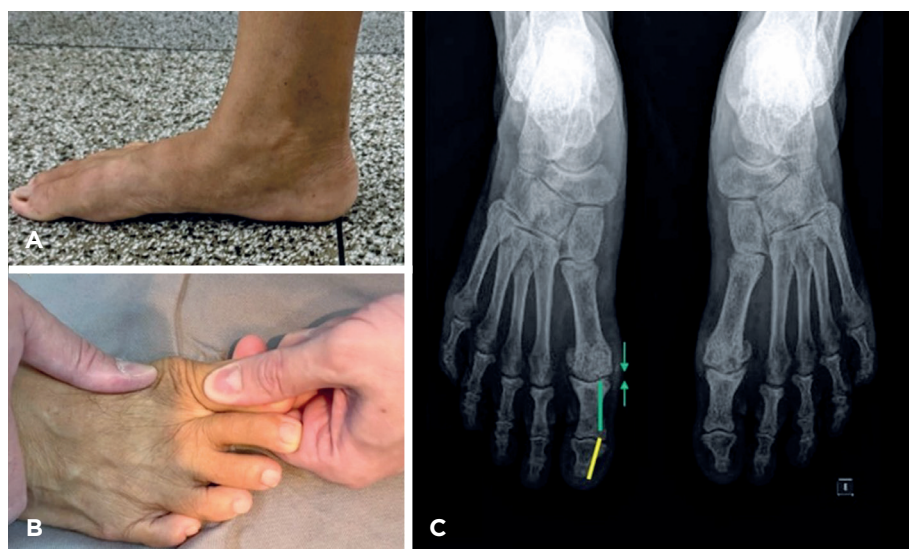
Clinical and radiographic evaluation of hallux rigidus. (A) Lateral view showing enlargement of the first metatarsophalangeal joint. (B) Physical examination demonstrating pain and marked limitation of motion, particularly dorsiflexion. (C) Anteroposterior and lateral radiographs showing near-complete joint space obliteration with extensive periarticular osteophyte formation.
